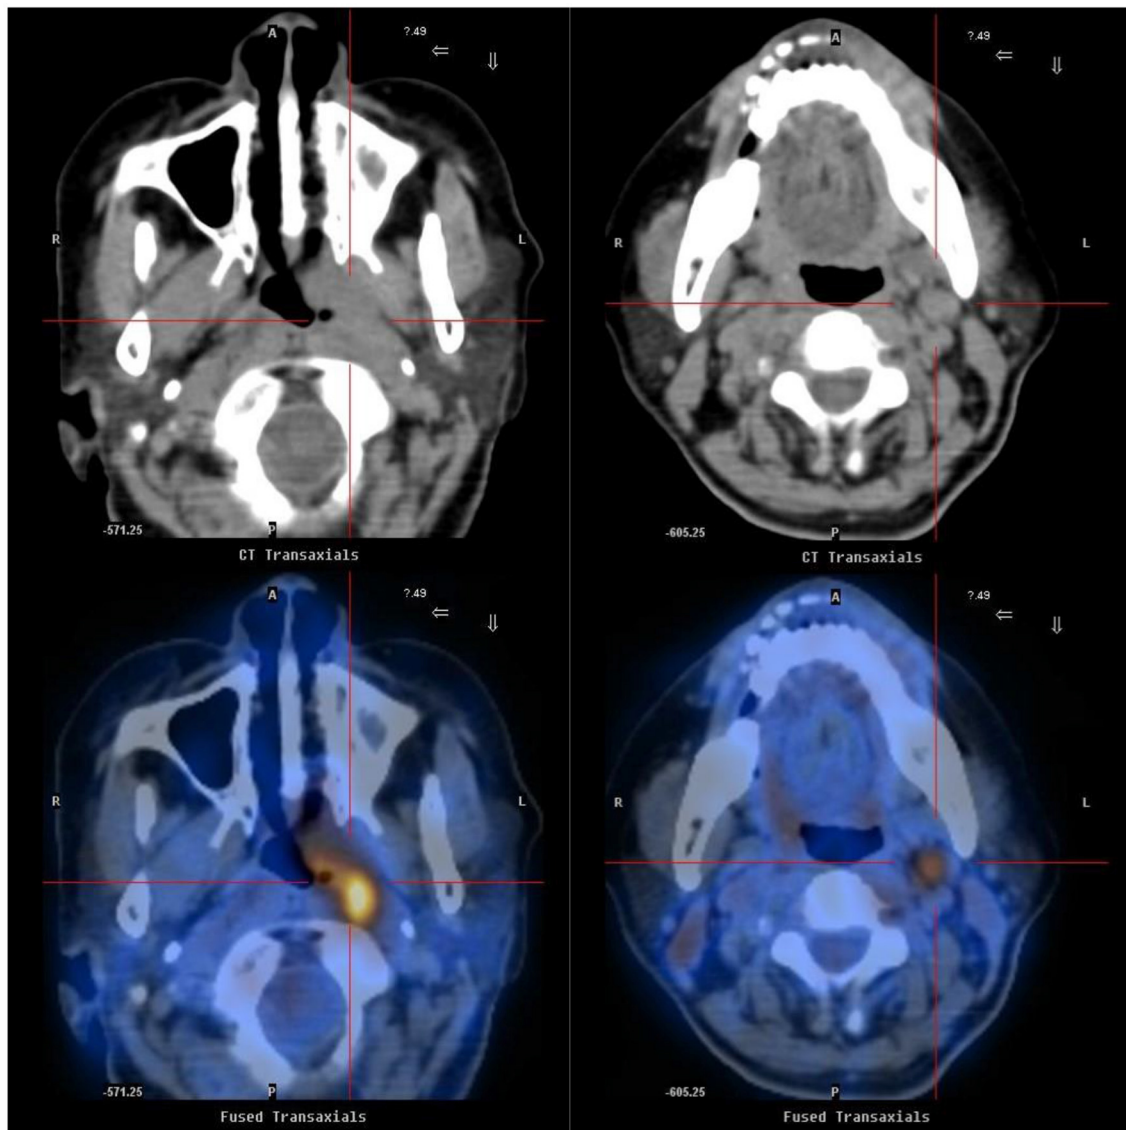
Positron emission tomography (PET) scan shows left nasopharyngeal carcinoma extending to carotid sinus. PET scan demonstrated an increased accumulation of FDG (2-deoxy-2-[^{18}F] fluoro-D-glucose) in the thickening left nasopharynx (left) and an increased accumulation of FDG in the left carotid sheath space (right).
